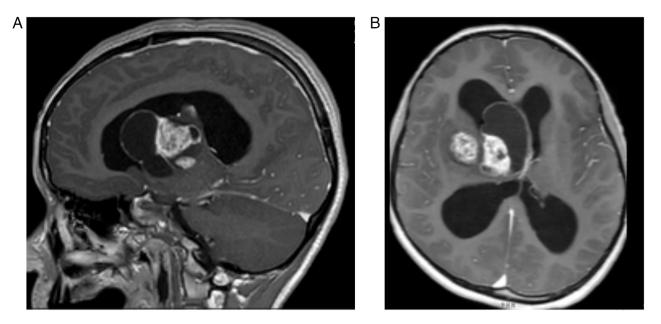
Case of a 13-year-old girl with a 2-week history of frontal headache, vomiting and three episodes of loss of consciousness. (A) MRI demonstrated the presence of a multiloculated, cystic, partially calcified left thalamic lesion, (B) extending into the lateral and the third ventricle, with a severe triventricular hydrocephalus.
